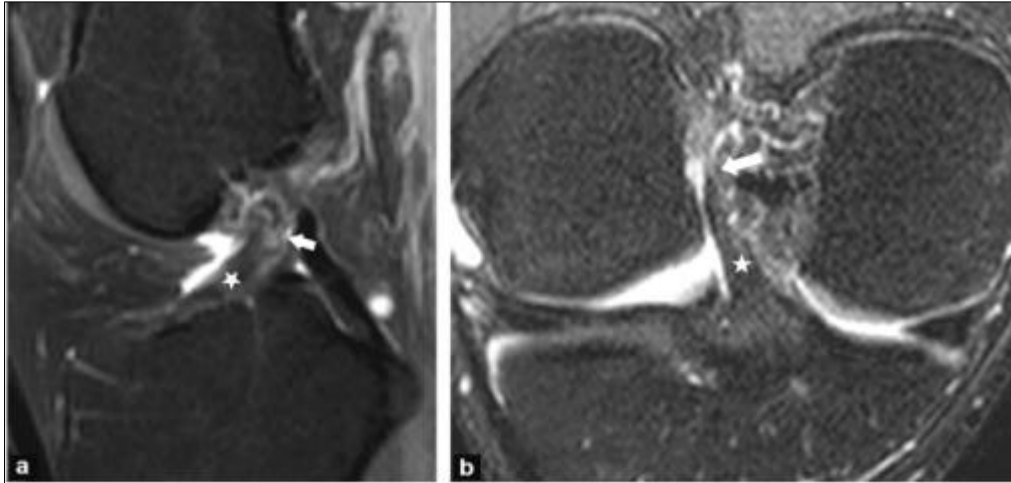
MRI image showing discontinuity of the anterior cruciate ligament (ACL).
